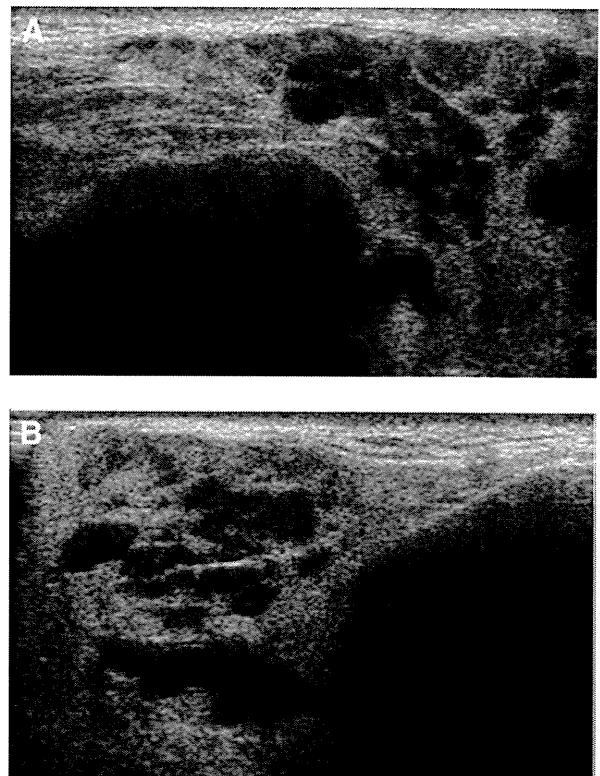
(A) Parotid gland sonogram which shows deterioration in the condition in a follow-up period. Multiple hypoechoic areas are distinct, however, adjacent parotid parenchyma are still within normal echo intensity level (scanned parallel to the Frankfort-Horizonral plane, left: anterior, right: posterior). (B) Same case as Fig. 6A (scanned parallel to the retromandibular plane, left: superior, right: inferior).
